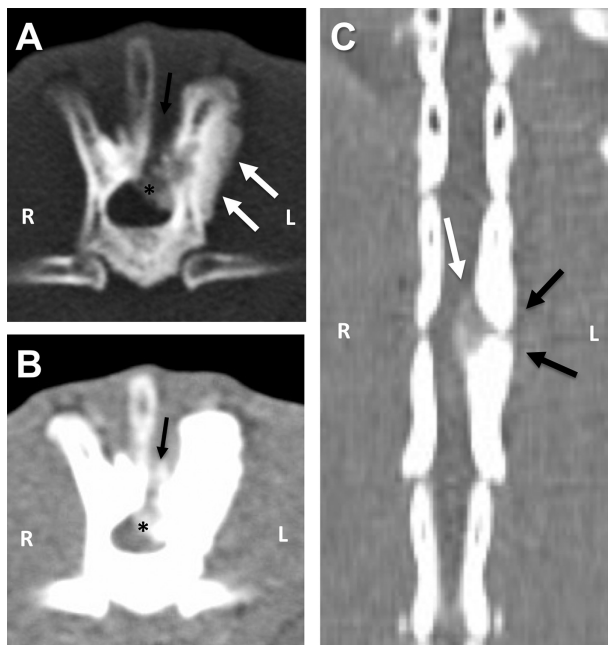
Computed tomographic images of the thoracic vertebral column of the patient in Figure 1, acquired at the level of the T11-12 articular process joint. Notice the smooth periosteal reaction delineating the left articular processes in the transverse plane image (A; white arrows). An osteolytic lesion is evident between the spinous process and lamina (B; black arrow). Dorsolateral spinal cord compression caused by an extradural lesion with soft tissue-attenuating characteristics is also present (asterisk). A dorsal reconstruction (C) demonstrates left-sided spinal cord compression (white arrow) and remodeling of the left caudal articular process of T11 and left cranial articular process of T12 (black arrows).
